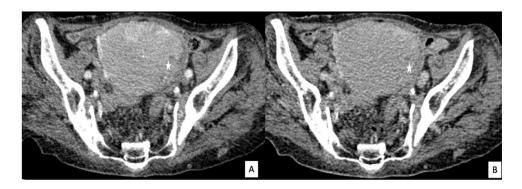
Axial CT images on both the arterial (A) and portal phase (B) showing a moderately enhancing mass (white asterisk) with early arterial phase enhancement and cystic areas.
